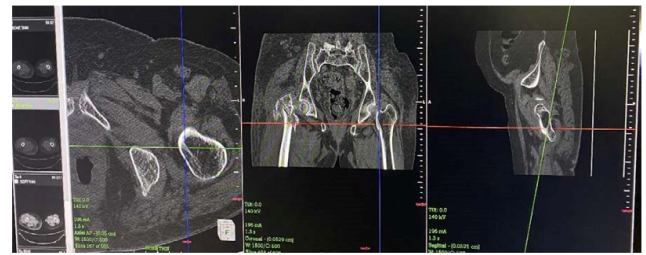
Showing the localization of the level of lesser trochanter in the CT scans (from left to right: transverse, coronal and sagittal sections) on the unaffected side
